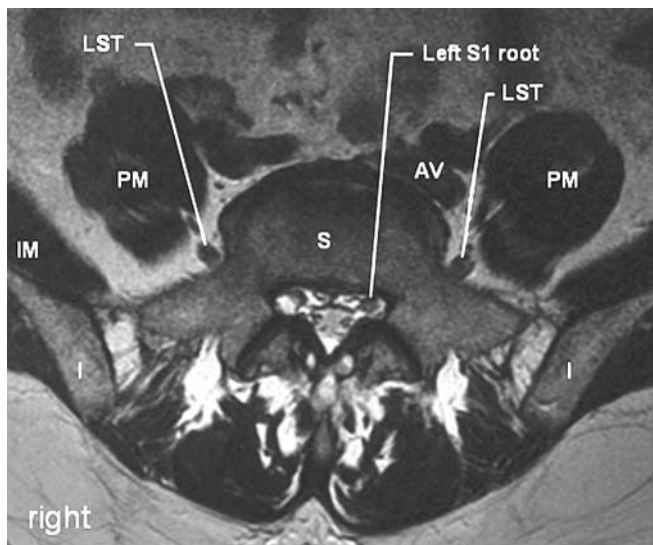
T2- weighted axial MRI at S1 level. AV arterio-venous bundle, I ilium, IM iliacus muscle, LST lumbosacral trunk, PM psoas major muscle, S sacrum
